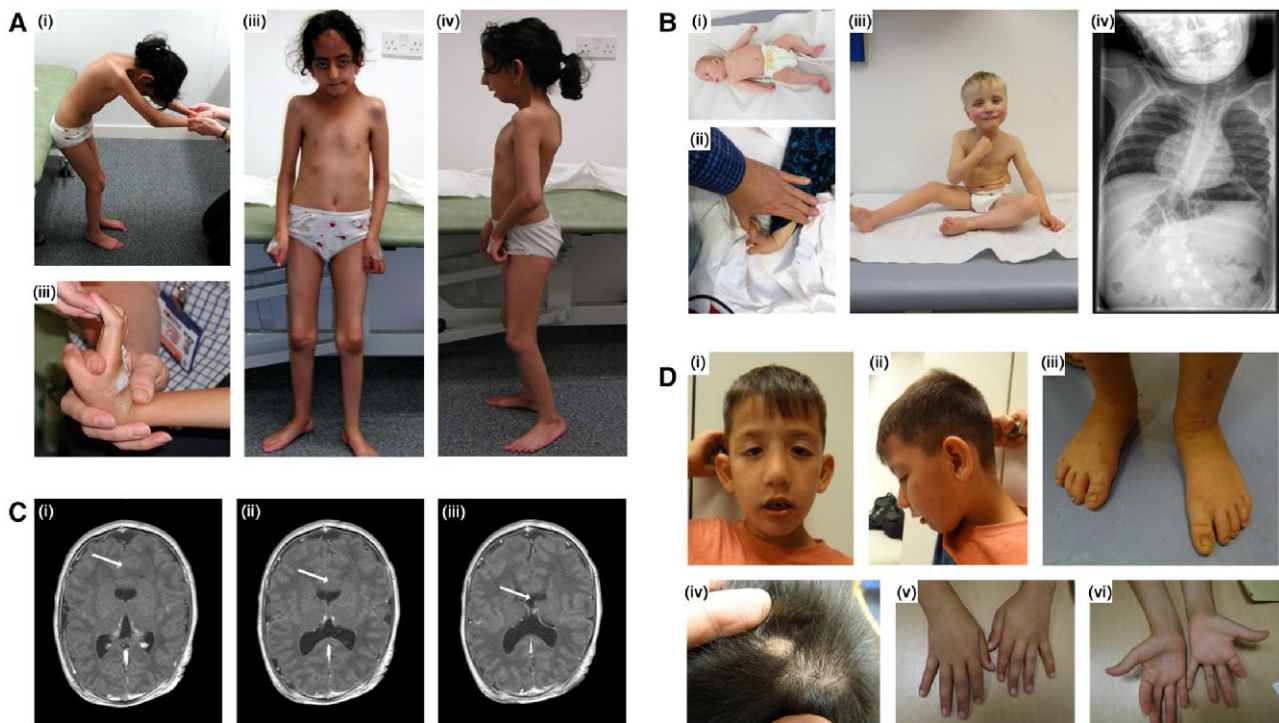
Presentation of disease features found in our cohort *FILIP1*-patients defining the congenital syndrome. (A) Female Patient 1 from Family A with homozygous p.[Arg57*] *FILIP1* variants. Clinical findings include neck webbing, rigid spine, kyphoscoliosis, elbow and knee flexion contractures and bilateral foot pronation as well as flexion contractures of the fingers (i–iv). Dysmorphic features include large forehead with prominent ridging of the metopic suture, large prominent ears, prominent nose and micrognathia, ptosis, myopathic face (iii and iv). Photographs were taken at the age of 9 years. (B) Male index patient from Family B with homozygous p.[Pro1133Leu] *FILIP1* variants. B(i) shows the patient as a floppy baby with congenital clubfeet and adducted thumbs and joint hyperlaxity is shown in ii. B(iii) shows the patient as a toddler (able to sit without support) presenting with ptosis, epicanthus, down-slanted palpebral fissures, hypertelorism, broad root of the nose/depressed nasal bridge. B(iv) shows severe scoliosis found in this patient. Photographs/images were taken at the age of 4 months (i), 2.5 years (ii) and 3.5 years (iii and iv). (C) shows a lobar holoprosencephaly with agenesis of corpus callosum (indicated by arrows) in Patient 4 from Family C. MRI was carried out at the age of 14 days. (C) shows Patient 5 from Family D presenting with protruding ears, ptosis, epicanthus, down-slanted palpebral fissures, hypertelorism, broad root of the nose/depressed nasal bridge (i and ii). Foot abnormalities are not present (iii). D(iv) shows residual material of an occipital encephalocele. D(v and vi) show single transverse palmar crease on the left hand, but otherwise absence of major anomalies. Photographs were taken at the age of 5 years and 9 months.
